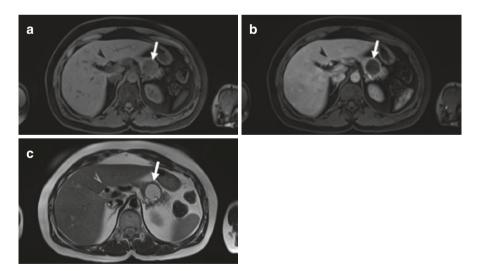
Serous cystadenoma. MRI (a, T1WFS; b, T1WFS w/gad arterial phase; c, T1WFS w/gad portal venous phase; d, T2W axial MRCP) shows a lesion composed of small cysts in the tail of the pancreas (*arrow*). The lesion has thin, enhancing septa but no nodularity or soft tissue component
